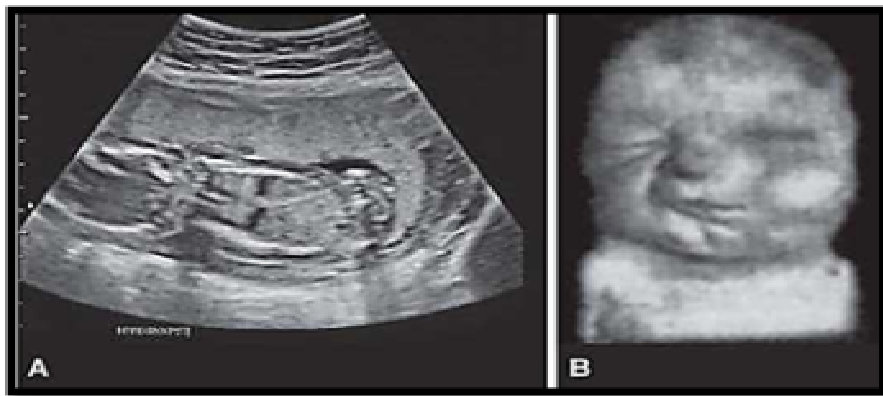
An example of a deformation is the potter syndrome. Note the severe oligohydramnios seen on ultrasound (A) and (B) a fetus with Potter syndrome (*Purandarey, 2009*).
